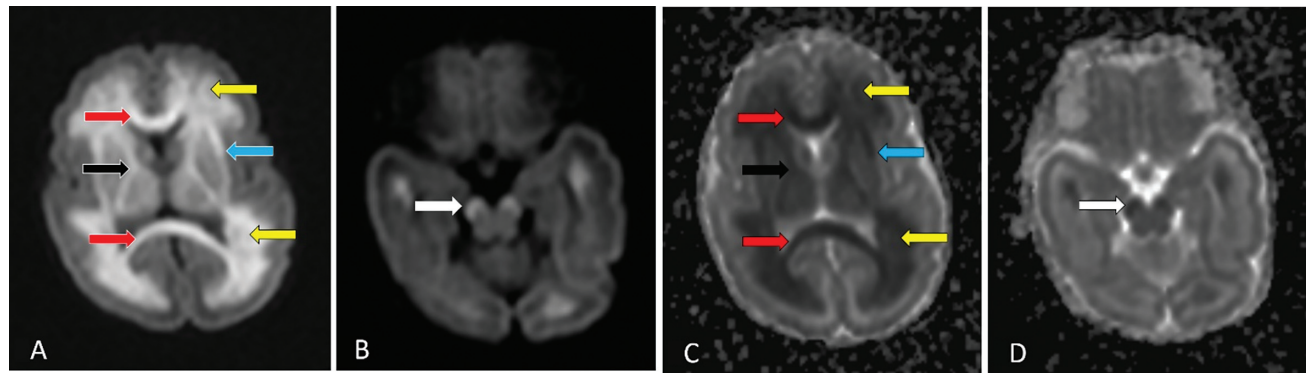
Diffusion weighted imaging (DWI) showing (A) diffuse, symmetric, bilateral hyperintensities involving frontal and temporal white matter (yellow arrows), internal capsule (black arrow), external capsule (blue arrow), corpus callosum (red arrow) and (B) crux cerebri (white arrow), which show restriction as seen in the (C, D) corresponding images on the addition diffusion coefficient (ADC).
